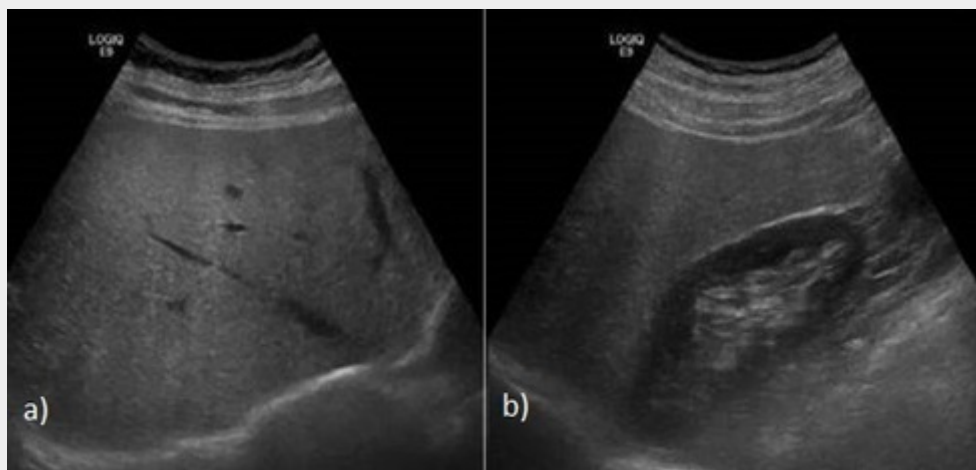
Ultrasound images in a patient with diffuse hepatic steatosis showing increased hepatic parenchyma echogenicity (a). Note the reflectivity differences between the liver and the right kidney (b).
